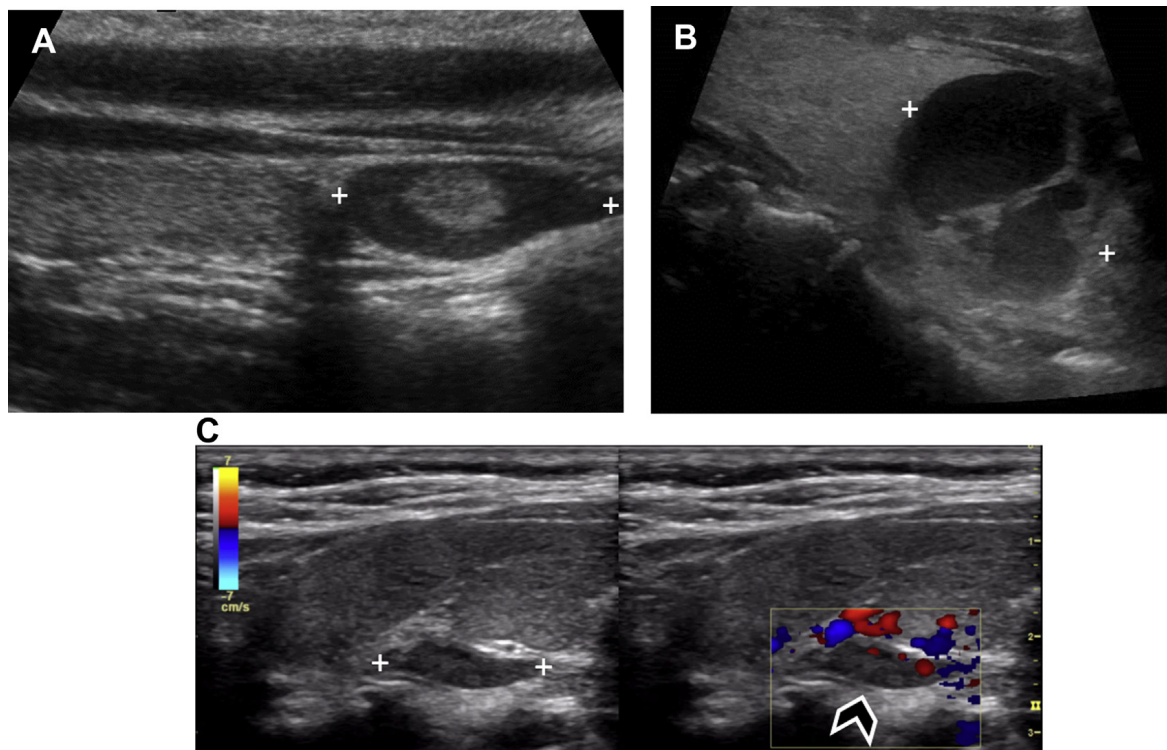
Examples of atypical sonographic appearance of parathyroid adenomas (cursors) in different patients containing (A) internal echogenic components, (B) cystic spaces, and (C) minimal detectable internal flow (arrowhead), as seen on side-by-side grayscale and color Doppler images.
